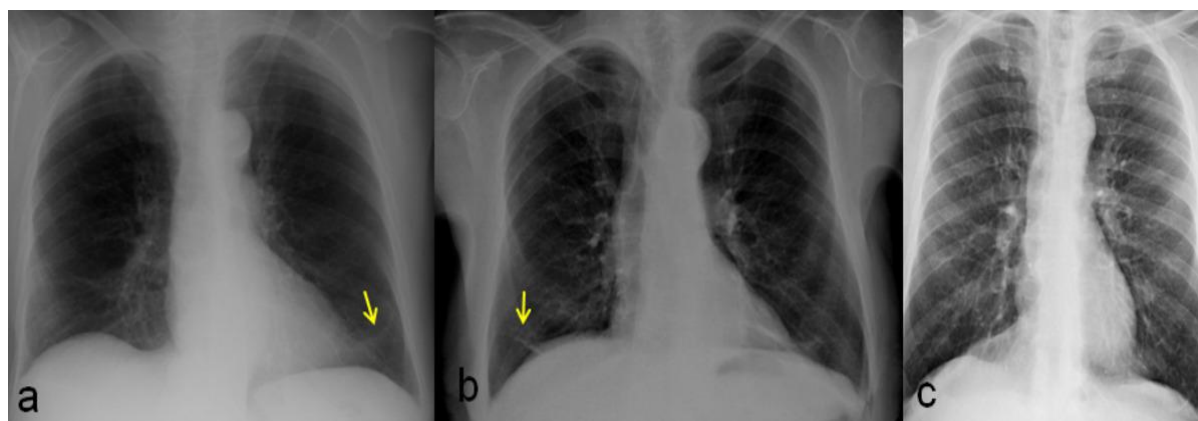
Chest X-ray (a) in a 92-year-old woman with a pancreatic cancer, showing diffuse hyperlucency, with bronchial wall thickening and diffuse hypoperfusion, due to "elderly lung"; lamellar atelectasia (yellow arrow). Frontal chest X-ray (b) in a 68-year-old man shows diffuse bronchial wall thickening associated with medium-degree obstruction detected with respiratory functional tests. This patients has COPD. Lamellar atelectasia (yellow arrow). Frontal chest X-ray (c) in a 74-year-old man shows diffuse bronchial wall thickening with no respiratory functional tests changes.
